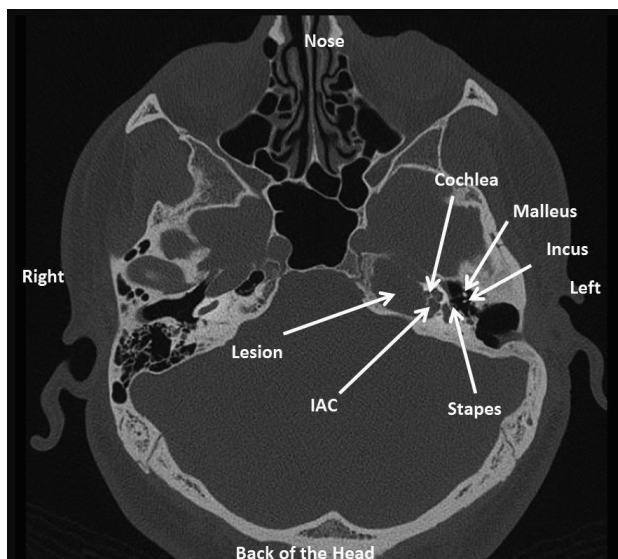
Axial CT image of the patient showing the petrous apex mass with large dehiscence (exposed) cochlea and IAC.
